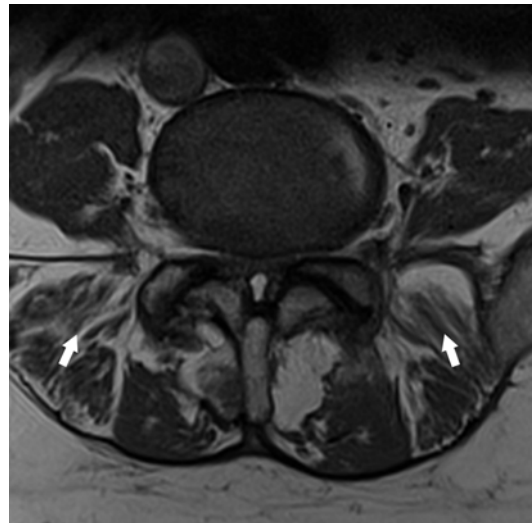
L4-L5 facet joint osteoarthritis associated with paraspinal muscle atrophy with fatty replacement (*arrows*) visualized on axial T1 MR image. Severe canal stenosis secondary to posterior disk bulge and facet hypertrophy is present
